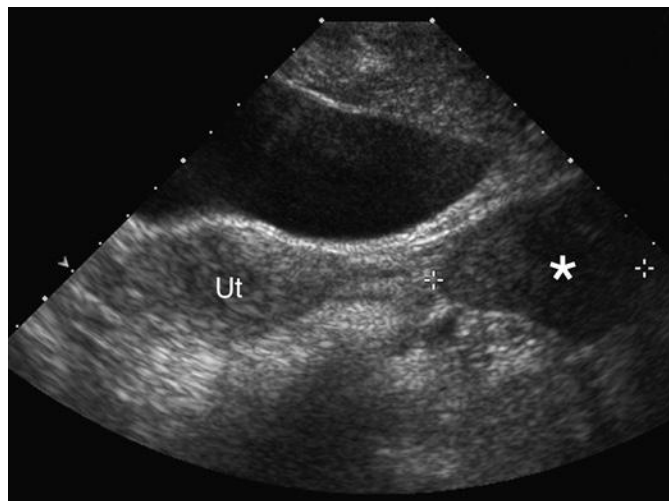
Transverse abdominal sonogram. A left adnexal solid mass (*asterisk and calipers*) is seen. Although the location would make one think of an ovarian mass, it was in fact a broad ligament myoma. Ut, uterus.
